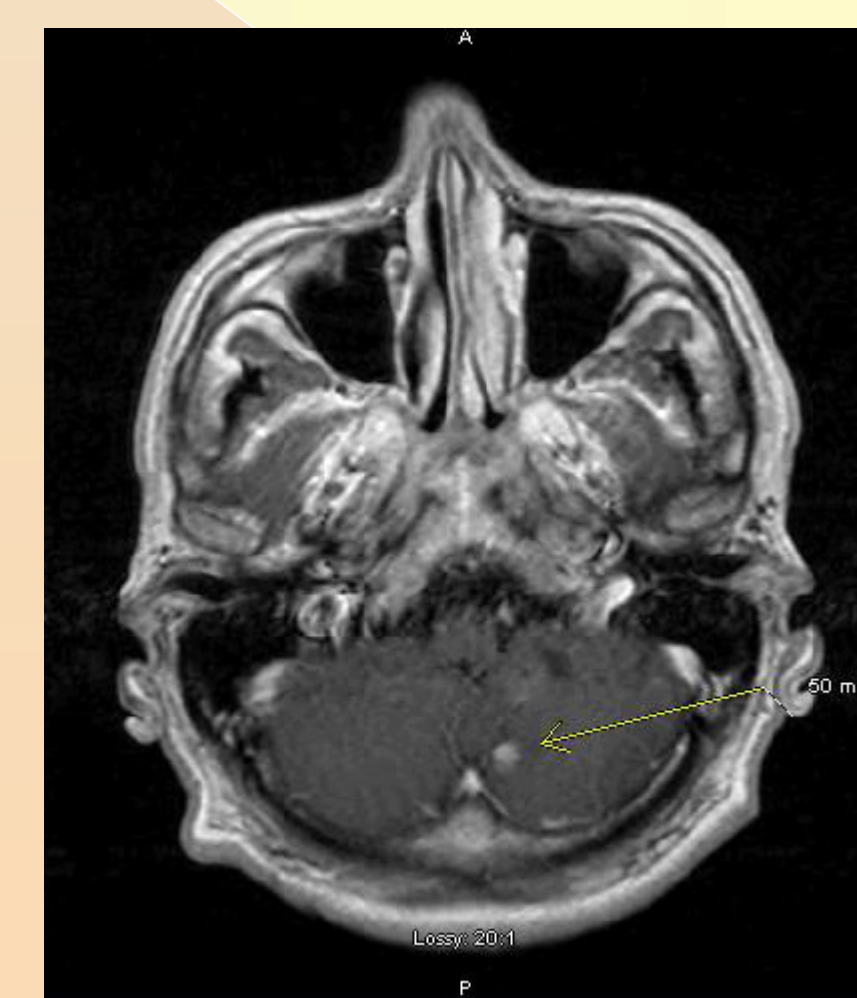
MRI T1 Axial + GAD showing cerebellar lesion. 2014
